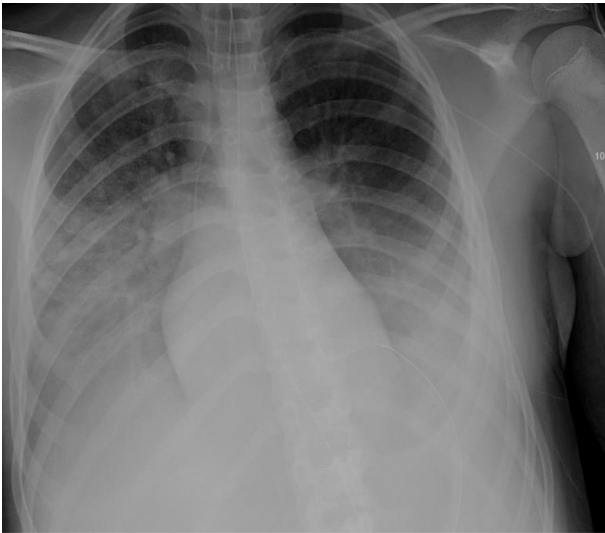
Chest X-ray, anteroposterior (AP) view on the day with remdesivir trial commenced (hospital day 8).
